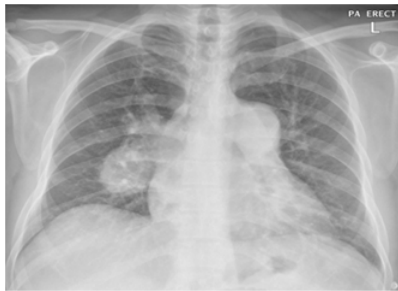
X-ray chest Frontal projection: Enlarged both hila, more on left side and right infra hilar soft tissue opacity. Otherwise lung fields are clear with clear costophrenic angles. Heart size not enlarged.
